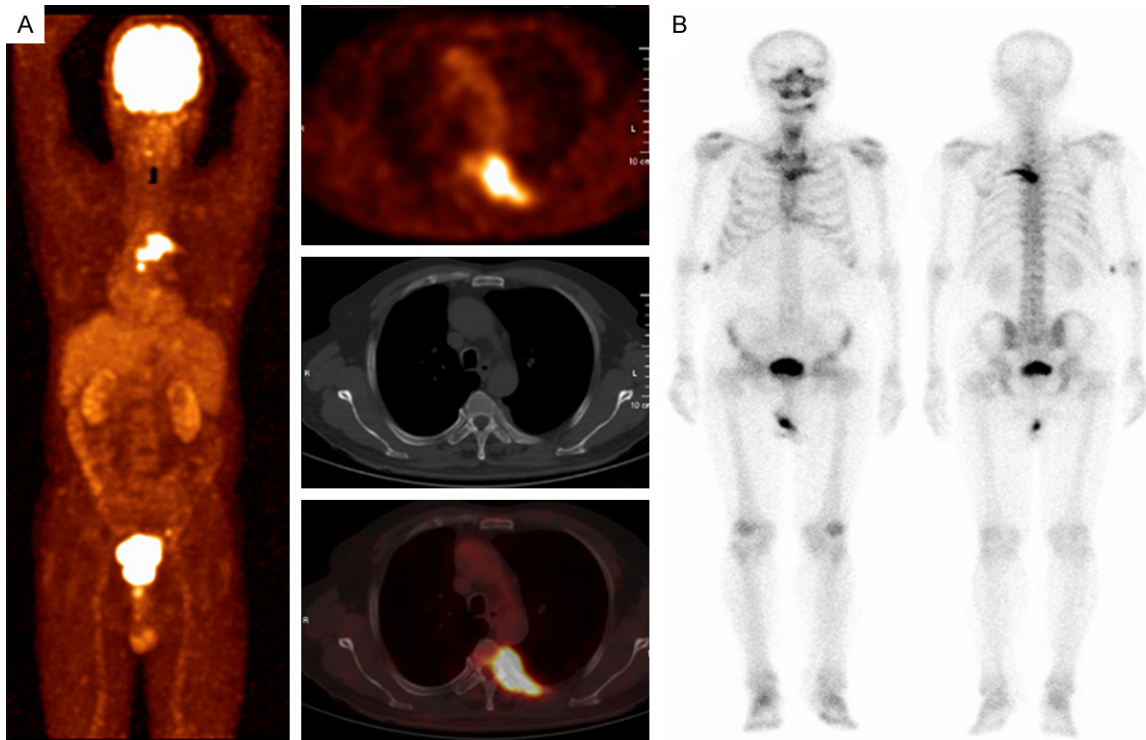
^{18}F -FDG PET/CT showed remarkable uptake in the fourth, fifth, and sixth vertebral body as well as the fifth posterior rib without obvious destruction of bone (SUVmax = 10.6) (A). $^{99\text{m}}\text{Tc}$ -MDP bone scan also revealed intense MDP accumulation in the same region (B).
